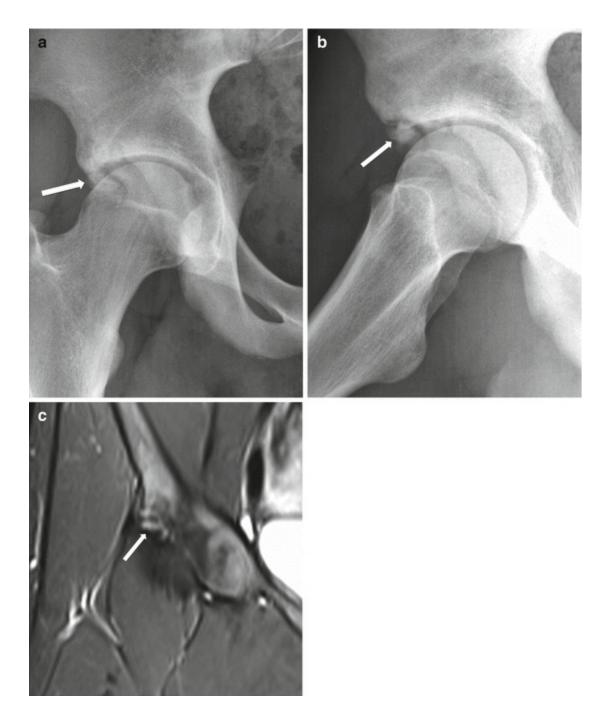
A 16-year-old female athlete with an old fracture avulsion of the right superior acetabular ridge at the insertion of the indirect head of rectus femoris. (a) Anteroposterior and (b) frog leg lateral x-rays of the right hip show an osseous fragment detached from the superior acetabulum (arrow). (c) Coronal fat-suppressed T2-weighted MRI displays fracture of the superior acetabulum at the insertion of the indirect head (arrow)
